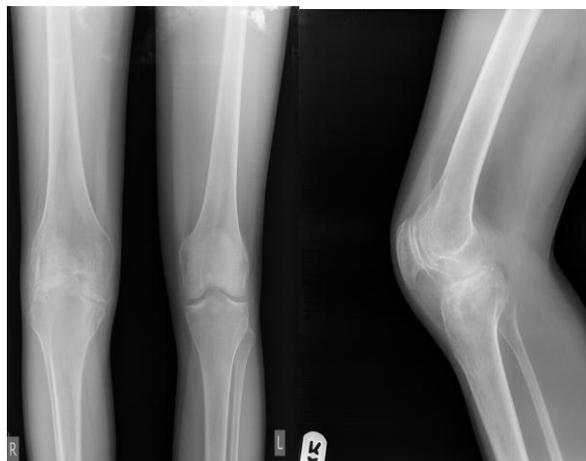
Preoperative X-ray of the patient's knee.
